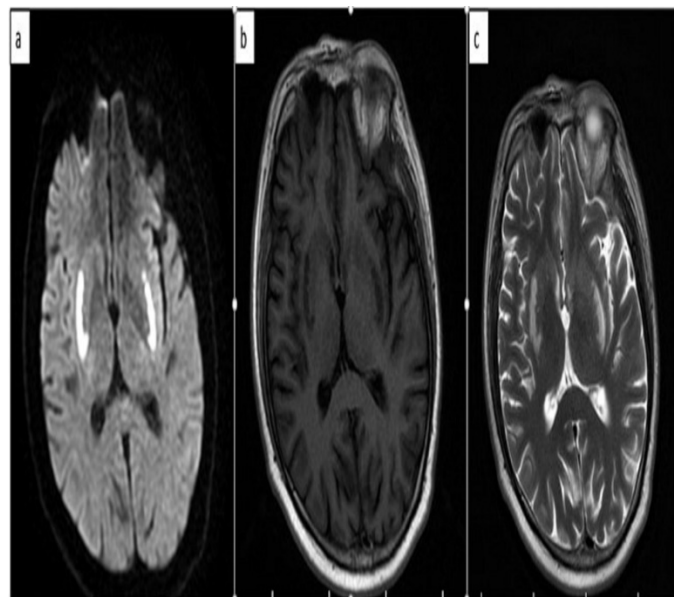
(a): Brain MR image without contrast showing bilateral symmetrical changes in the putamen. Hypo intensity in T1W axial image. (b): Hyperintensity signal changes in T2W axial image. (c): Diffusion restriction in DW axial image
